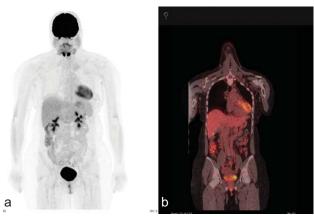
¹⁸FDG PET/CT (A: Maximum Intensity Projection MIP; B: Fused Coronal Image) in a normal individual. Vascular uptake is lesser than hepatic uptake.
